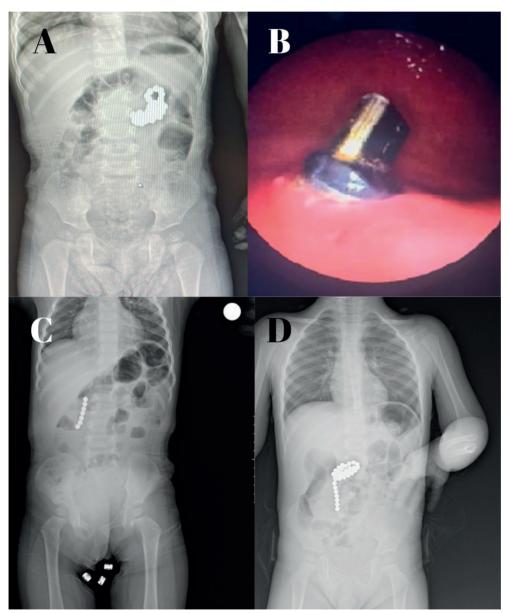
A) Radiographic image of magnets in the stomach of an 18-month-old female, who ingested 41 magnets. B) Endoscopic image of the stomach in a 20-month-old male. C) Radiographic image of magnets in the duodenum and colon (hepatic flexure) of a 12-month-old male, who ingested seven magnets. D) Radiographic image of magnets in the stomach and jejunum of a 24-month-old female, who ingested 27 magnets.
